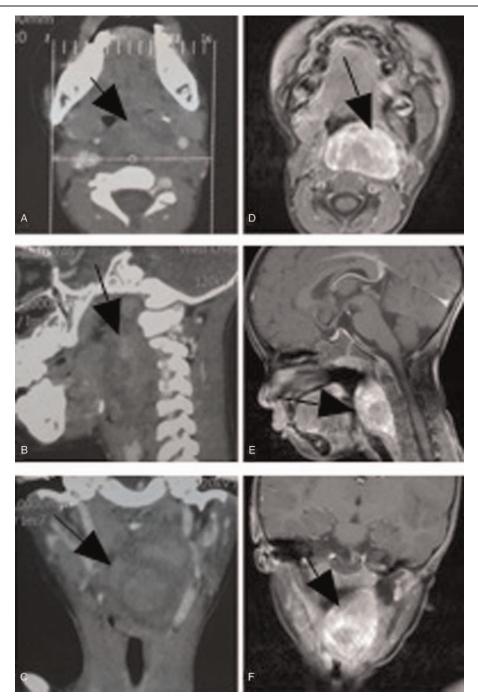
Preoperative computed tomographic (CT) and magnetic resonance imaging (MRI) images. (A–C) CT showed a giant mass with irregular low density in left oropharyngeal and posterior pharyngeal wall. The left carotid artery sheath was pushed to the right. After enhancement, the central part of the mass was strengthened, and the surrounding bones structures appeared normal. (D–F) MRI showed a solid mass in the left parapharyngeal space displacing the left carotid sheath posteriorly and laterally. CT=computed tomographic, MRI=magnetic resonance imaging.
